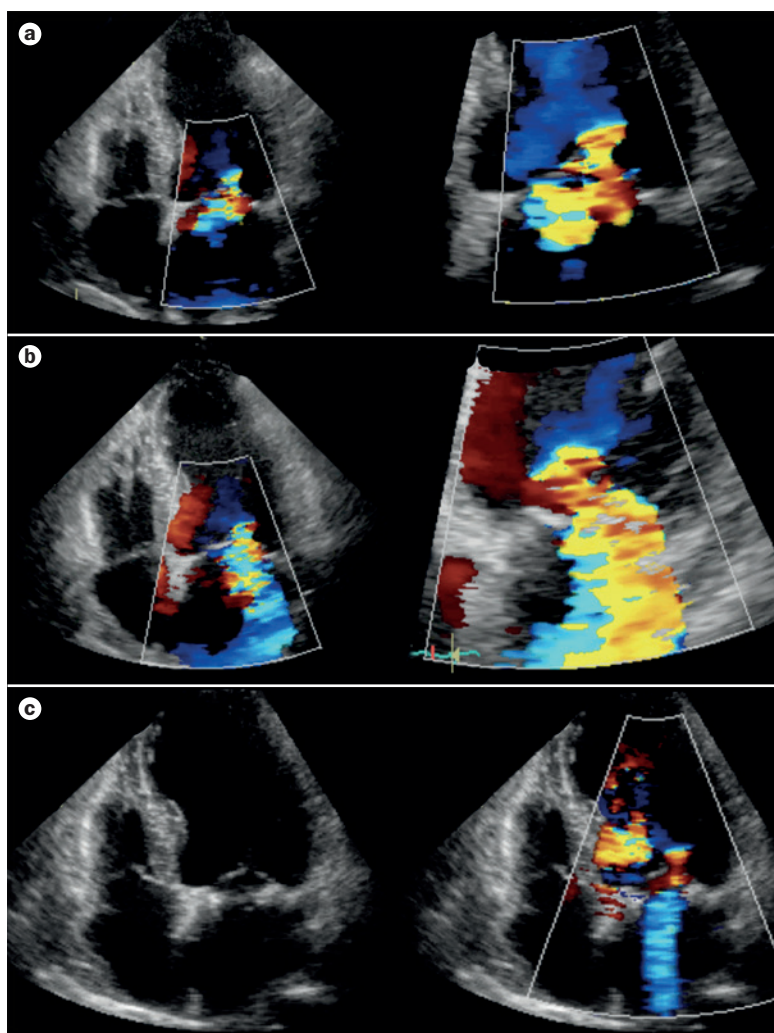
Transthoracic Doppler echocardiogram of a patient with symptomatic ischaemic cardiomyopathy, severe left ventricular dysfunction, and moderate secondary mitral regurgitation at rest. a | Patient at rest. b | During exercise, a clinically significant increase in mitral regurgitation combined with dyspnoea and pulmonary hypertension was observed. c | After CABG surgery and mitral valve repair, the patient improved clinically and no substantial increase in mitral regurgitation was observed during exercise.
